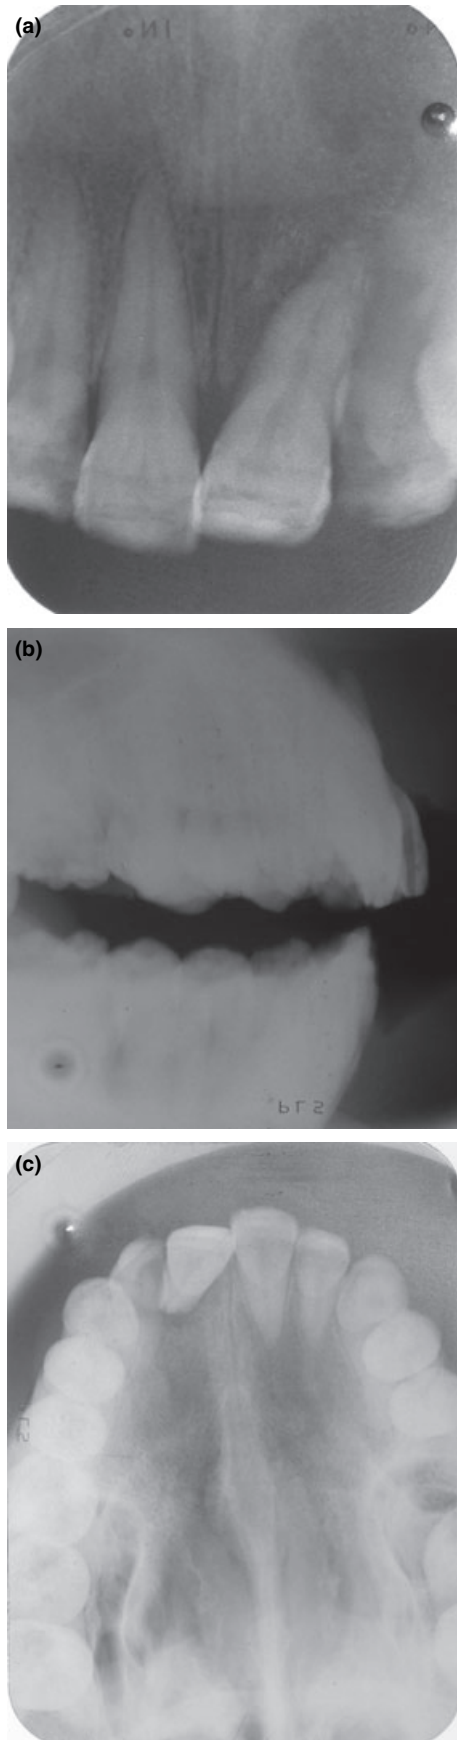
(a) Frontal periapical radiograph, taken from an extreme mesial angle, showing the tooth's displacement and an alveolar bone resorption on the mesial aspect of the root surface. (b) Lateral radiograph showing the displacement of the tooth. (c) Occlusal radiograph, taken from the mesial angle, showing the displacement of the tooth as well as bone resorption on the mesial and apical aspects.
